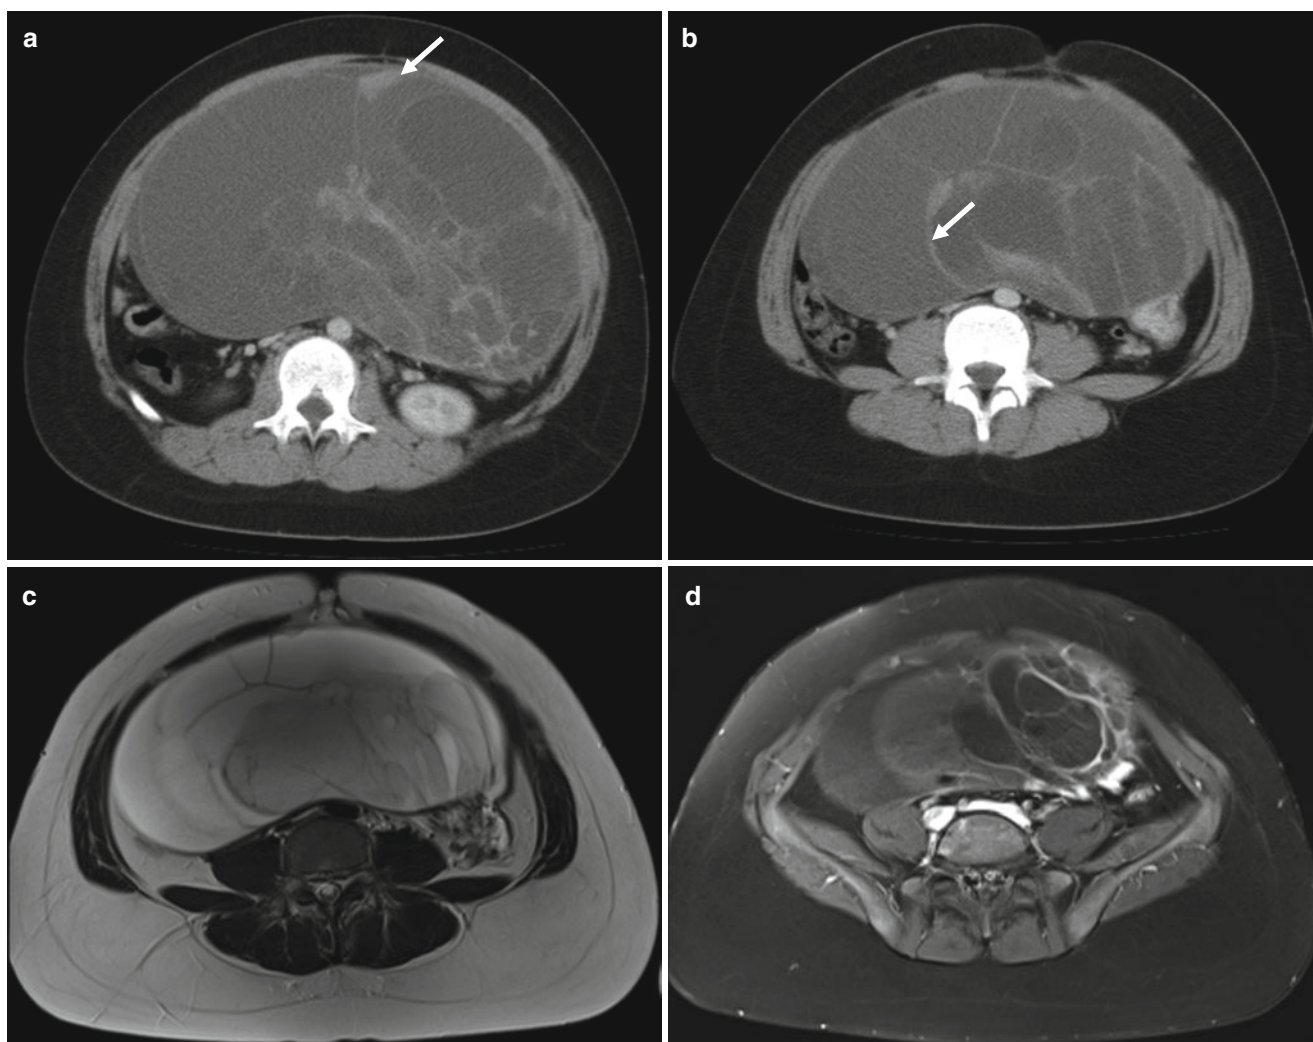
Mucinous tumor of borderline malignancy in a 16-year-old girl. (a, b) Contrast-enhanced CT scans show a large cystic mass with thick septa and nodular solid components (*arrows*). Note that the peripheral wall of the mass is thin and even. (c) T2-weighted axial MR
